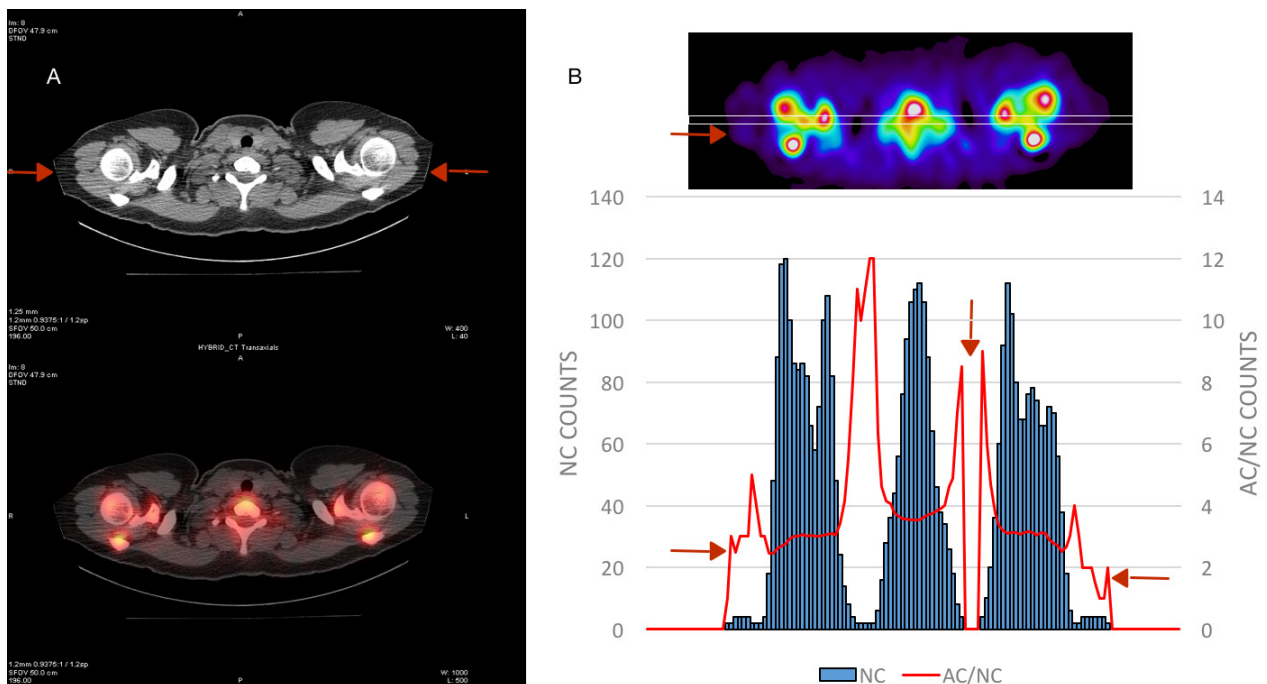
(A) A CT and fused SPECT/CT image of the neck and shoulder area showing truncation in both shoulders on the CT data, and (B) bone SPECT profile showing the NAC counts (blue) and the ratio of CTAC to NAC counts (red).
